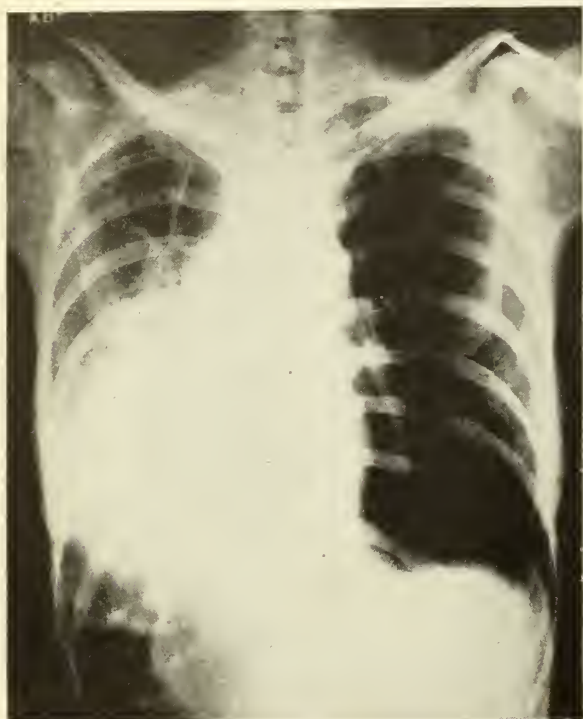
Same case as Figure 3, with collapse considerably lessened in degree. The diaphragm is still markedly elevated on the left, but the heart outline is noted just to the right of the midline. This roentgenogram was taken after employing Sante's maneuver on June 10, 1927.
